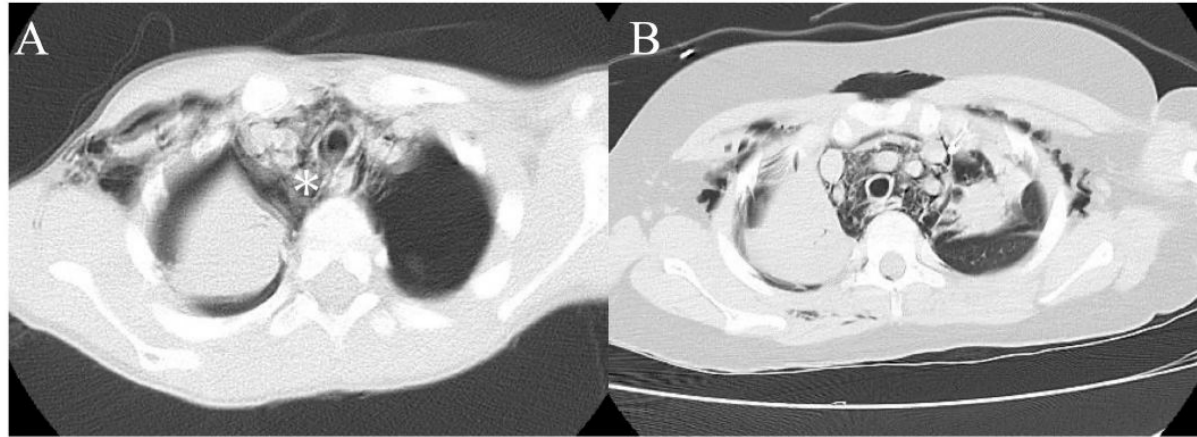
Chest CT. (A) Axial chest CT image of Case 1 showing severe pneumomediastinum (asterisks) with air tracking along the bronchovascular bundles and associated subcutaneous emphysema in the chest wall. (B) Axial chest CT image of Case 2 demonstrating similar findings, including severe pneumomediastinum.
